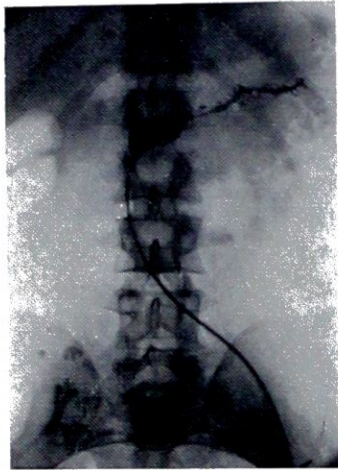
Radiograph of lipiodol injection of the pancreatic fistula. (Sir Geoffrey Keynes.)
